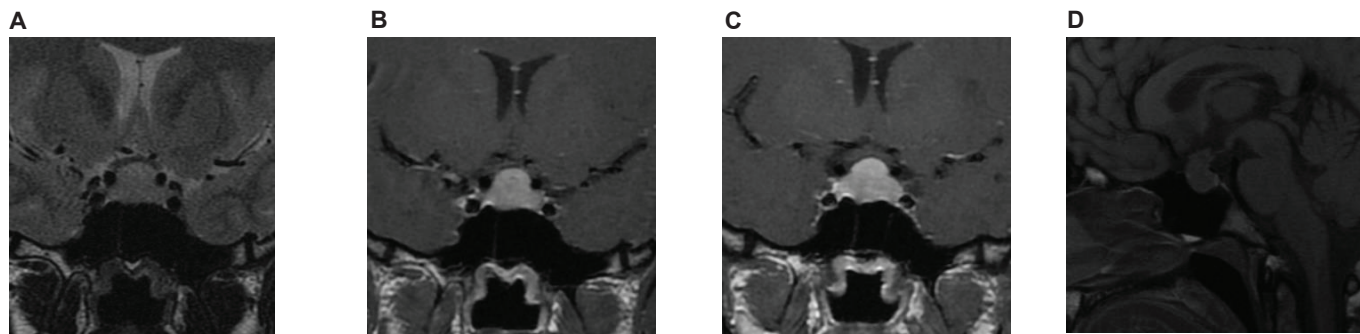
Coronal (A, B and C) and sagittal (D) pituitary MRI showing an enlarged pituitary gland with suprasellar extension.
